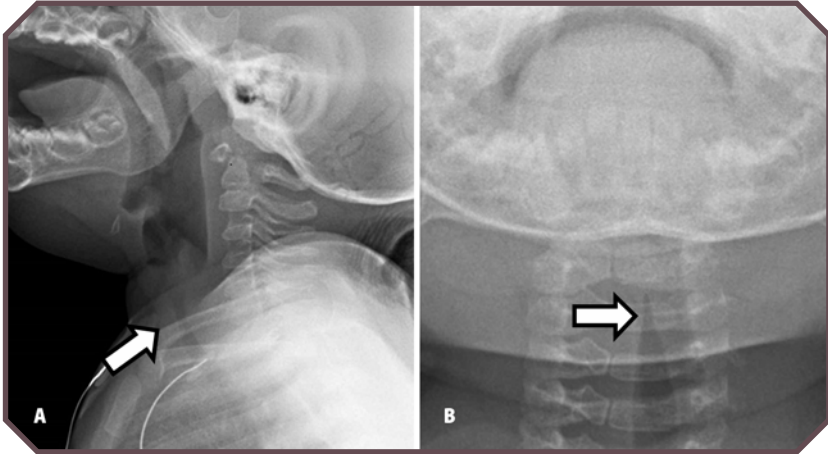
Croup in a 1-month-old female infant with stridor. A. Lateral and B. frontal radiographs demonstrate hyperinflation of the hypopharynx, subglottic narrowing, and the steeple sign, which are typical of croup (arrows).
